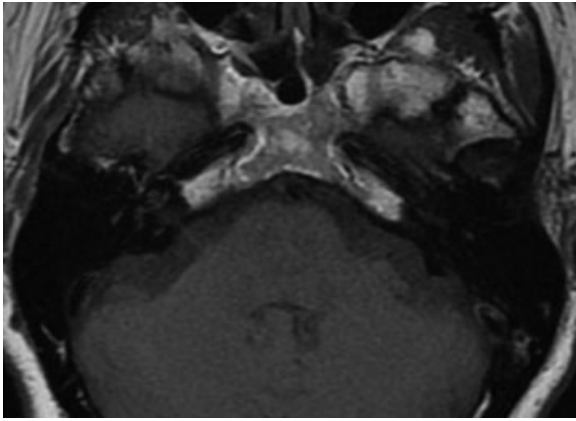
Axial T1-weighted magnetic resonance image evidencing an isointense mass on T1 limited to the right cochlea.
